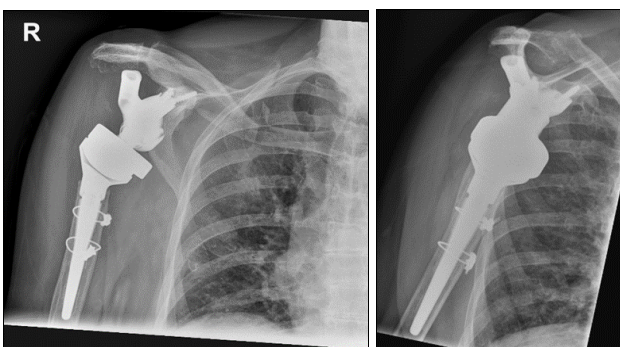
Radiographs showing post-operative images of custom-made revision implant.
